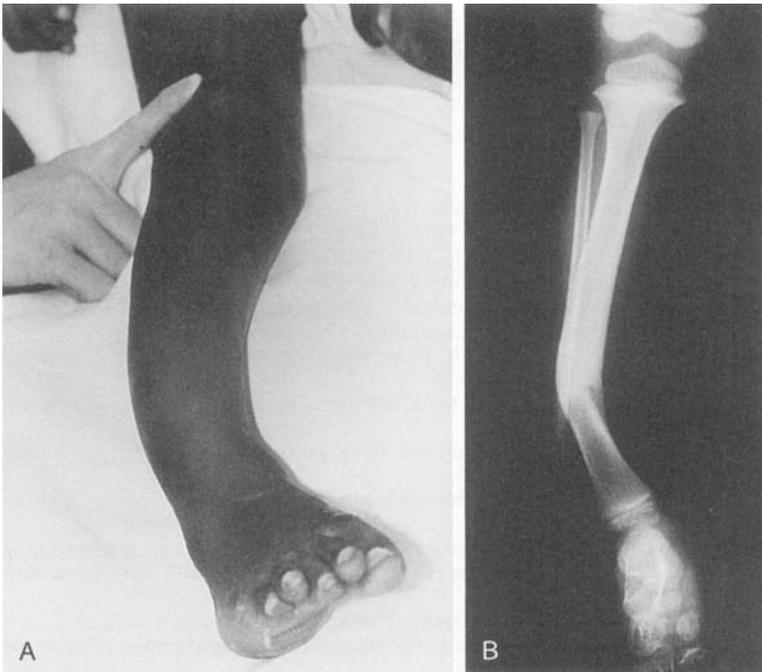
Congenital pseudarthrosis (CPT). The photograph (A) and radiograph (B) show the anterolateral bowing deformity of CPT. Protective orthotic management must be instituted early. Despite management, many children progress to fracture and persistent nonunion (pseudarthrosis).
